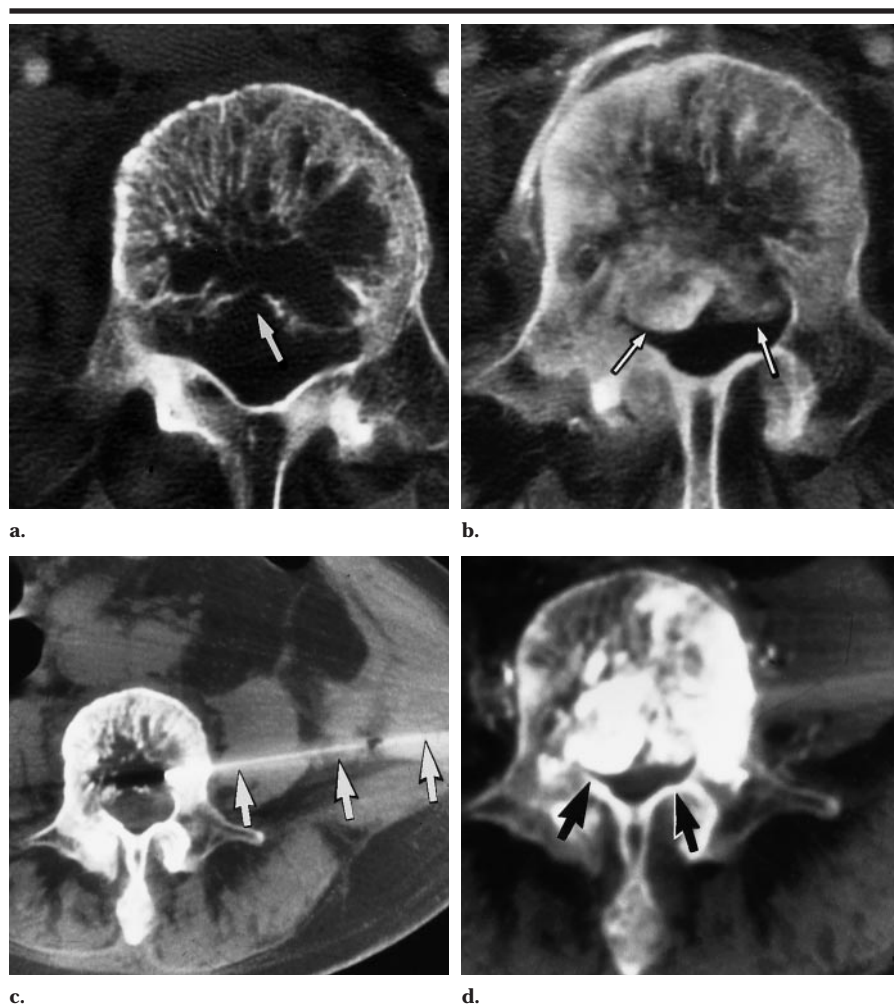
Patient 3. Extensive hemangiomatous lesion of L4 in a 73-year-old woman. Severe back pain and radiculopathy failed to respond to embolization or radiation therapy (3,500 rad [35,000 mGy]). (a) Transverse CT scan reveals extensive bone changes with posterior protrusion of cortex into the spinal canal. Note the focal cortical defect (arrow). (b) Transverse CT angiogram shows the central body to be avascular, but typical posterior protrusions (arrows) account for the root compression and symptoms. (c, d) Transverse CT scans show the needle (arrows in c) in the posterior portion of the vertebral body successfully fills both intraspinal components (arrows in d) with opacified ethanol. The transpedicle route probably would have failed in treatment of the intraspinal component.
